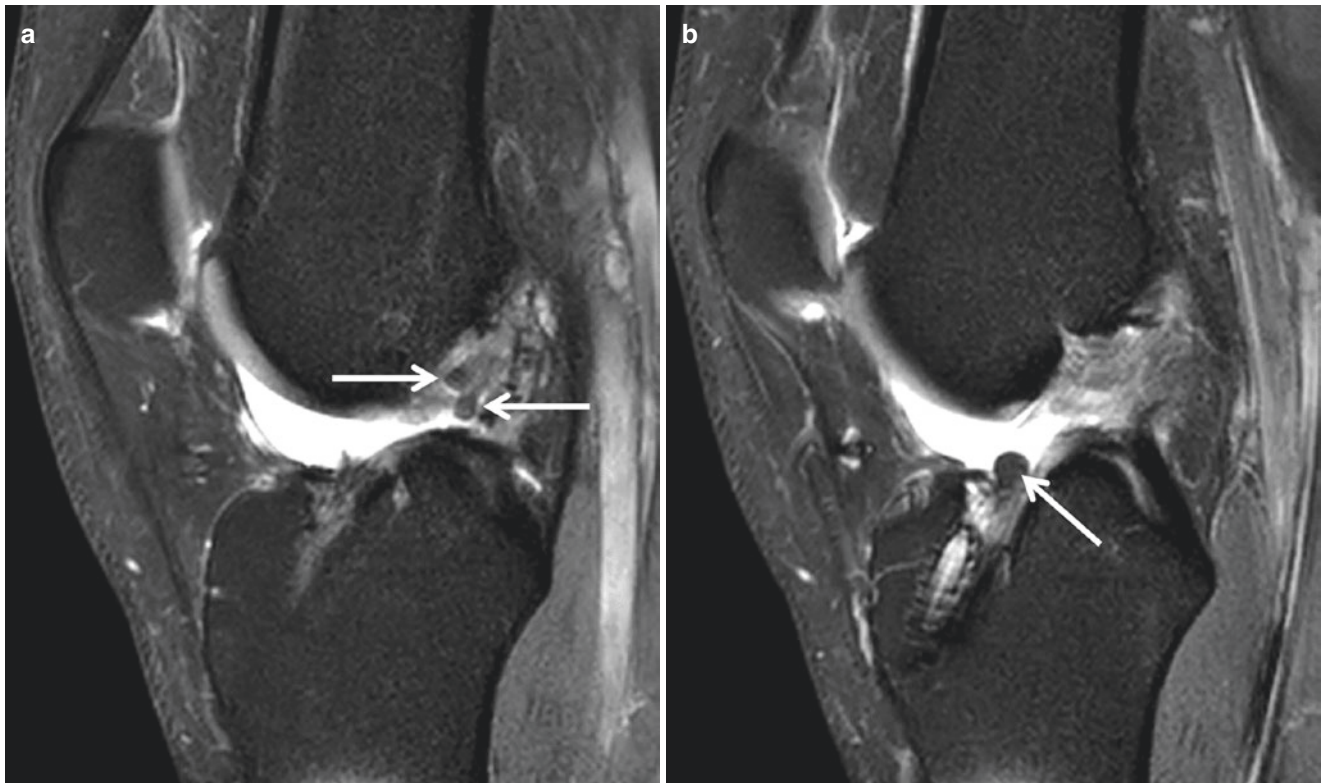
Graft rupture 3 years after anterior cruciate ligament reconstruction in A 25-year-old man. Sagittal fat-suppressed T2-weighted images show discontinuous (a) proximal and (b) distal graft fibers (arrows). Note presence of multiple strands in this hamstring autograft
